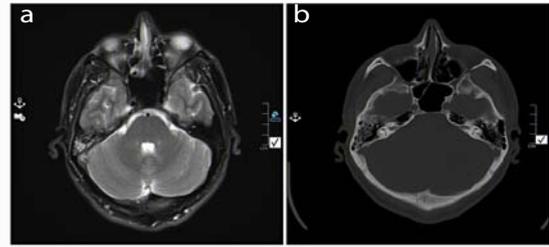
(a) On the axial T2, there is no flow void in the right transverse sinus due to the subacute T2 hyperintense thrombus. Note the adjacent right mastoid effusion. Venous thrombosis can be a complication of mastoiditis though in this case, (b) the CT earlier the same day demonstrated clear mastoids indicating that the effusion developed after the thrombus.
